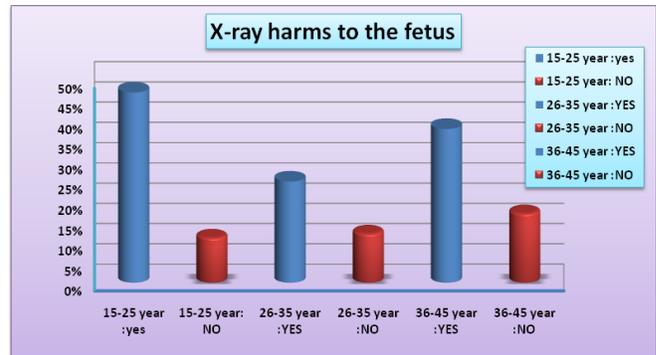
The percentage ratio of examination of the fetus with X-ray participant females.
